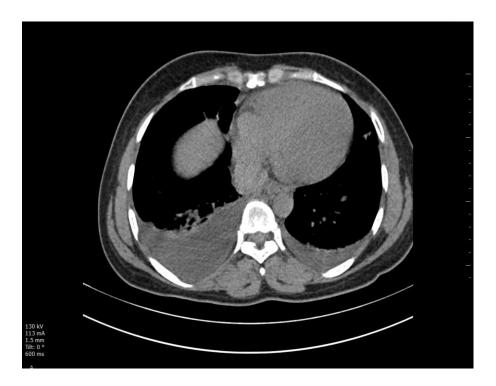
Computed Tomography image showing bilateral pleural effusion due to dengue fever.
